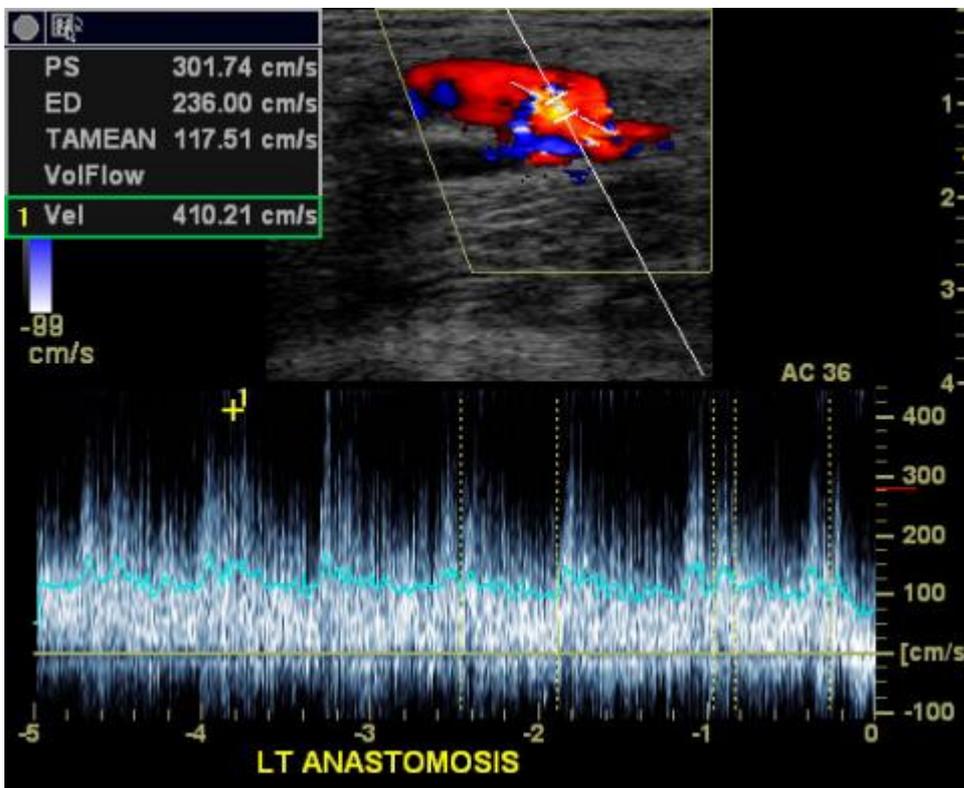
Spectral Doppler analysis of an AV fistula at the anastomosis. Normal flow at an AV fistula anastomosis is usually turbulent and high-velocity.
